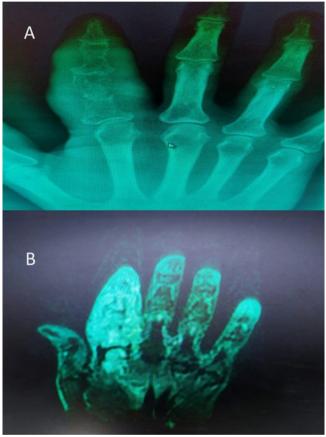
A; X- RAY OF THE HAND: dactylitis, inflammation of the index digit. B; MRI, extensive soft tissue mass lesion involving the whole index finger and extensive abnormal right bone marrow.
